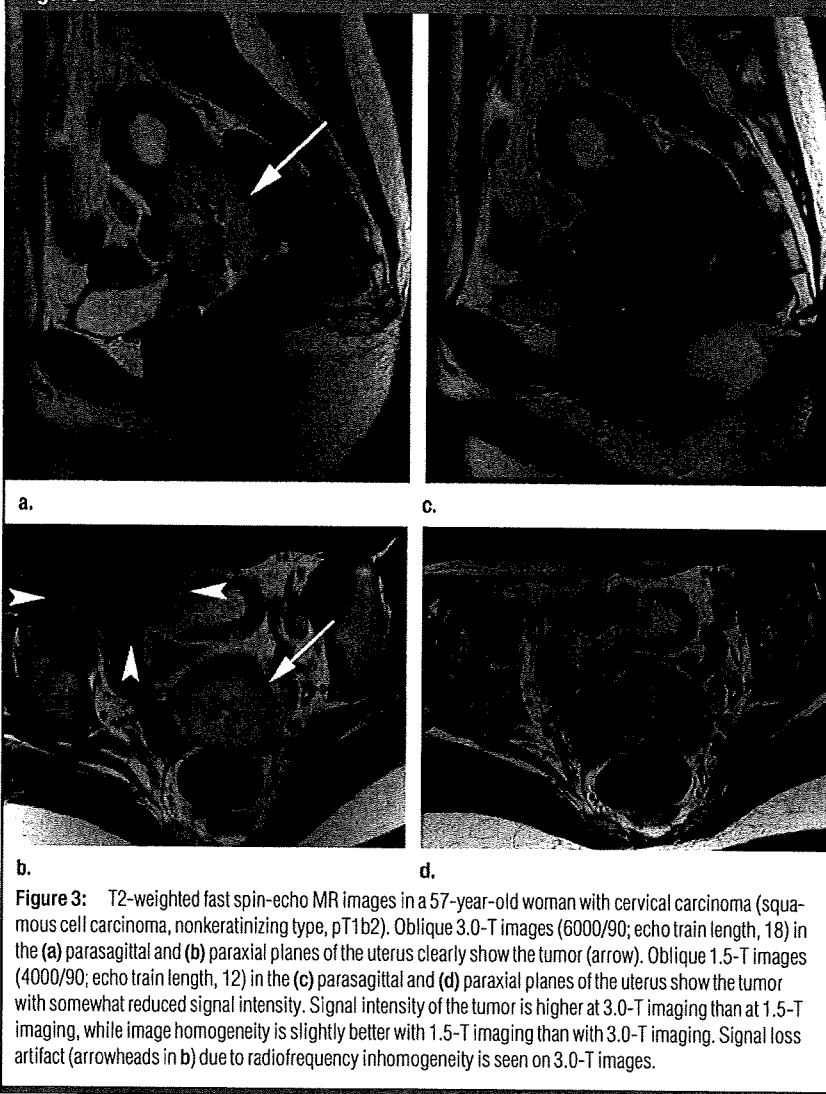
T2-weighted fast spin-echo MR images in a 57-year-old woman with cervical carcinoma (squamous cell carcinoma, nonkeratinizing type, pT1b2). Oblique 3.0-T images (6000/90; echo train length, 18) in the (a) parasagittal and (b) paraxial planes of the uterus clearly show the tumor (arrow). Oblique 1.5-T images (4000/90; echo train length, 12) in the (c) parasagittal and (d) paraxial planes of the uterus show the tumor with somewhat reduced signal intensity. Signal intensity of the tumor is higher at 3.0-T imaging than at 1.5-T imaging, while image homogeneity is slightly better with 1.5-T imaging than with 3.0-T imaging. Signal loss artifact (arrowheads in b) due to radiofrequency inhomogeneity is seen on 3.0-T images.
